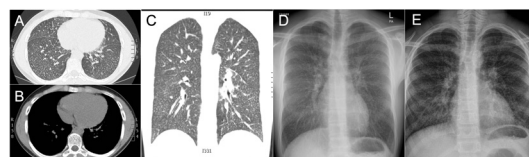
(A and C) High-resolution CT shows extensive bilateral poorly defined centrilobular ground-glass nodules. (B) No calcification is evident on the soft tissue window. (D) Chest X-Ray showing diffuse bilateral pulmonary nodules. (E) An old chest X-ray taken 9 years prior to presentation does not demonstrate appreciable changes over the years.
